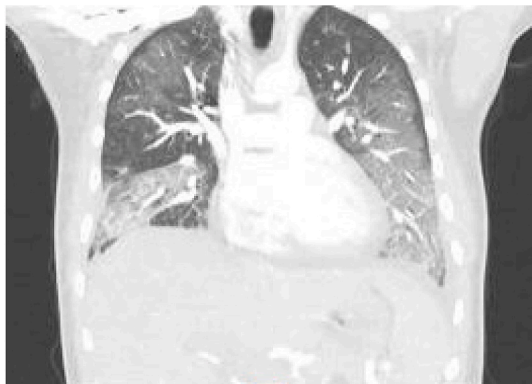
Coronal section of the CT chest showing diffuse bilateral ground glass opacities in lungs.
